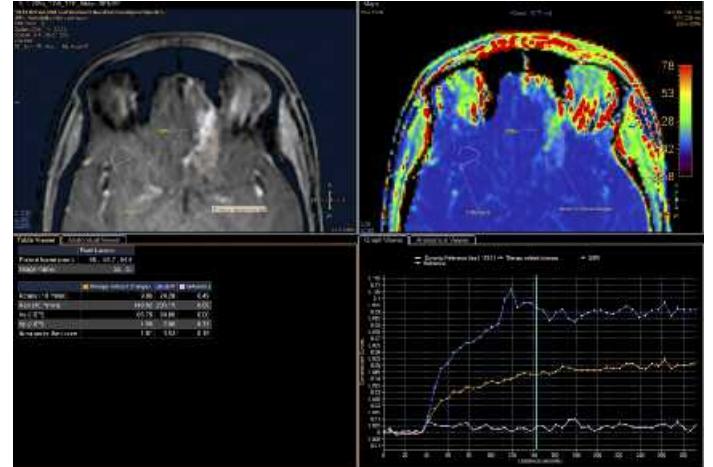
An 18-year old female previously underwent surgical resection in the frontobasal region and combined radio/chemotherapy for a GBM. Also, the MRI three months post-radiotherapy showed contrast enhancement, initially suspected for tumor progression. However, DCE-perfusion (data above) was able to show regions indicating lower forms of leakage (orange region of interest and curve), indicative of therapy related changes like radio-necrosis. The control MRI six weeks later confirmed this: no tumor progression but a further diminished enhancement in these regions.
